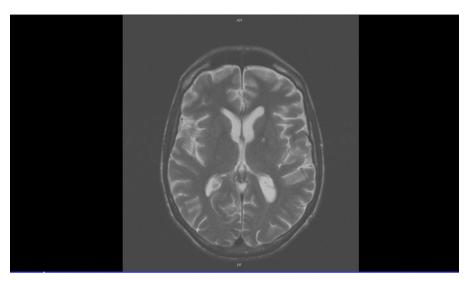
Brain MRI July 2014.
